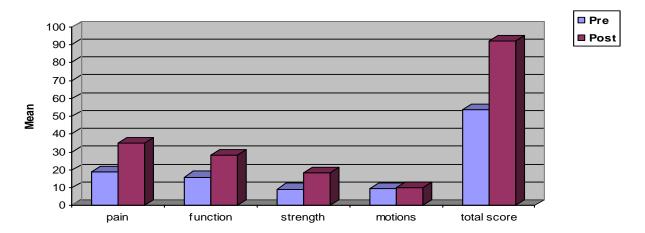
Within the ultrasound group differences.
